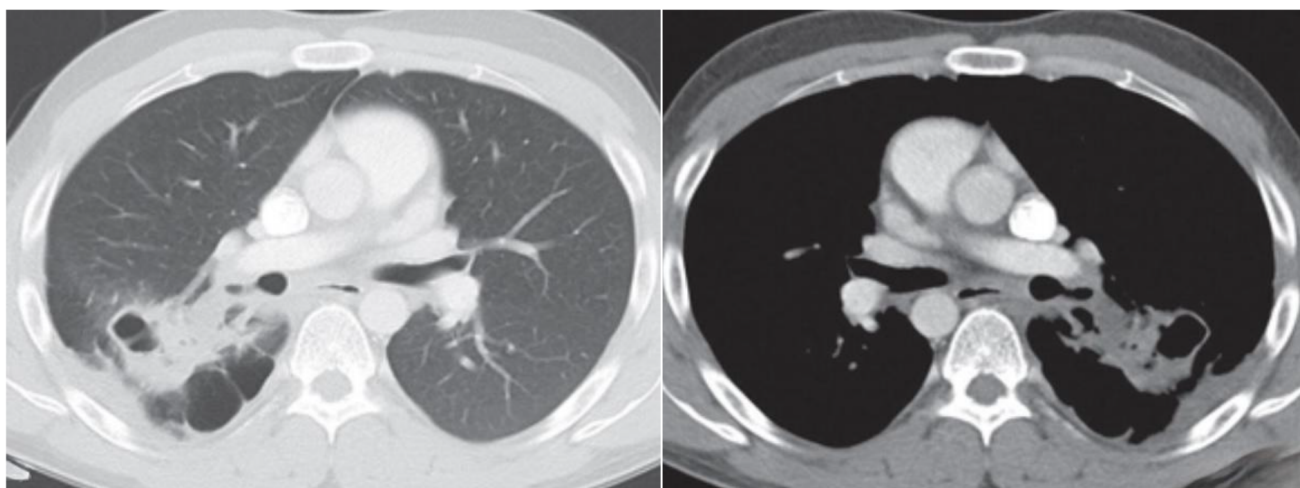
CT scan results.
